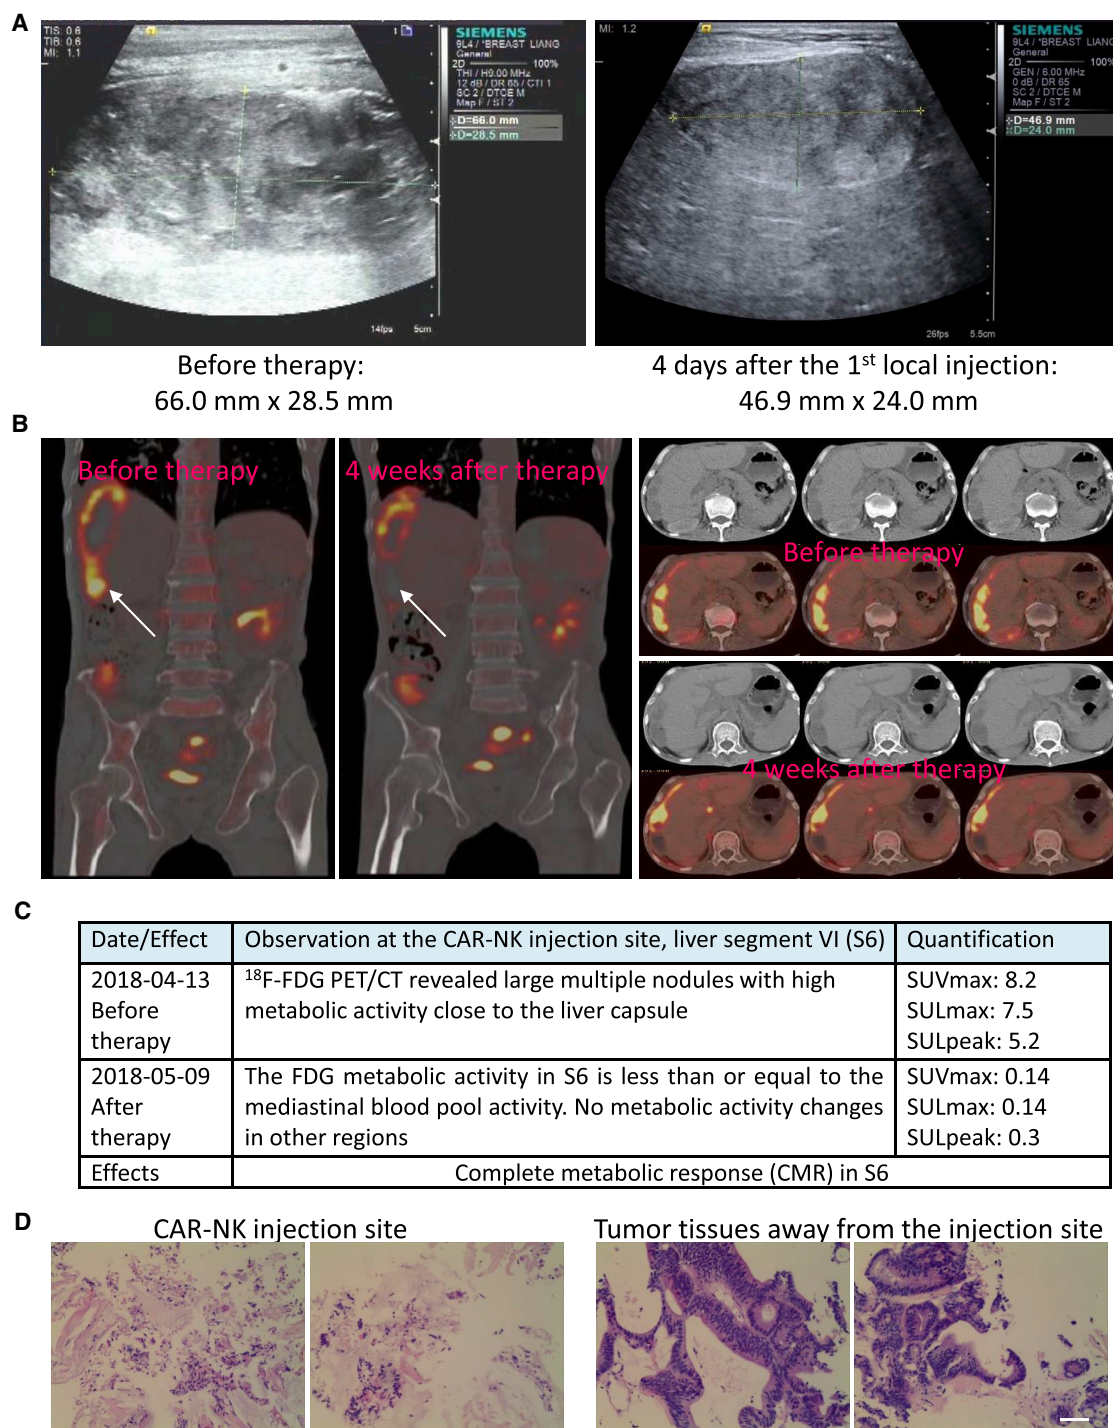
Effects of Ultrasound-Guided Local Injection of CAR-NK Cells on Metastatic Colon Cancer
